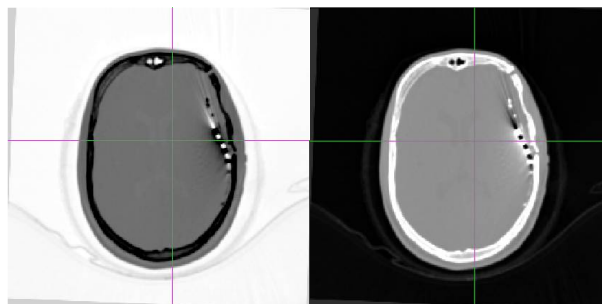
CT dataset from Patient 2. (Left) - Original CT image (Right) - CT image, after the correction of the sign of intensities.
